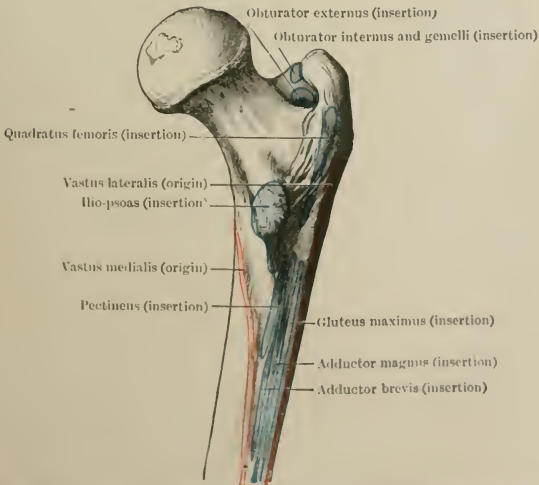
b*.—POSTERIOR ASPECT OF THE PROXIMAL PORTION OF THE RIGHT FEMUR, WITH ITS MUSCLE ATTACHMENTS.
